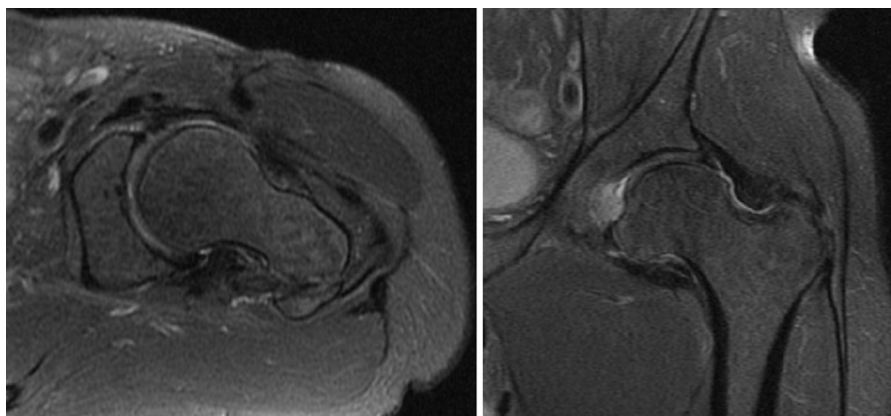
MRI showed no signs of osteonecrosis of femoral head; visualization of lesion of the anterior superior portion of the acetabular labrum.
